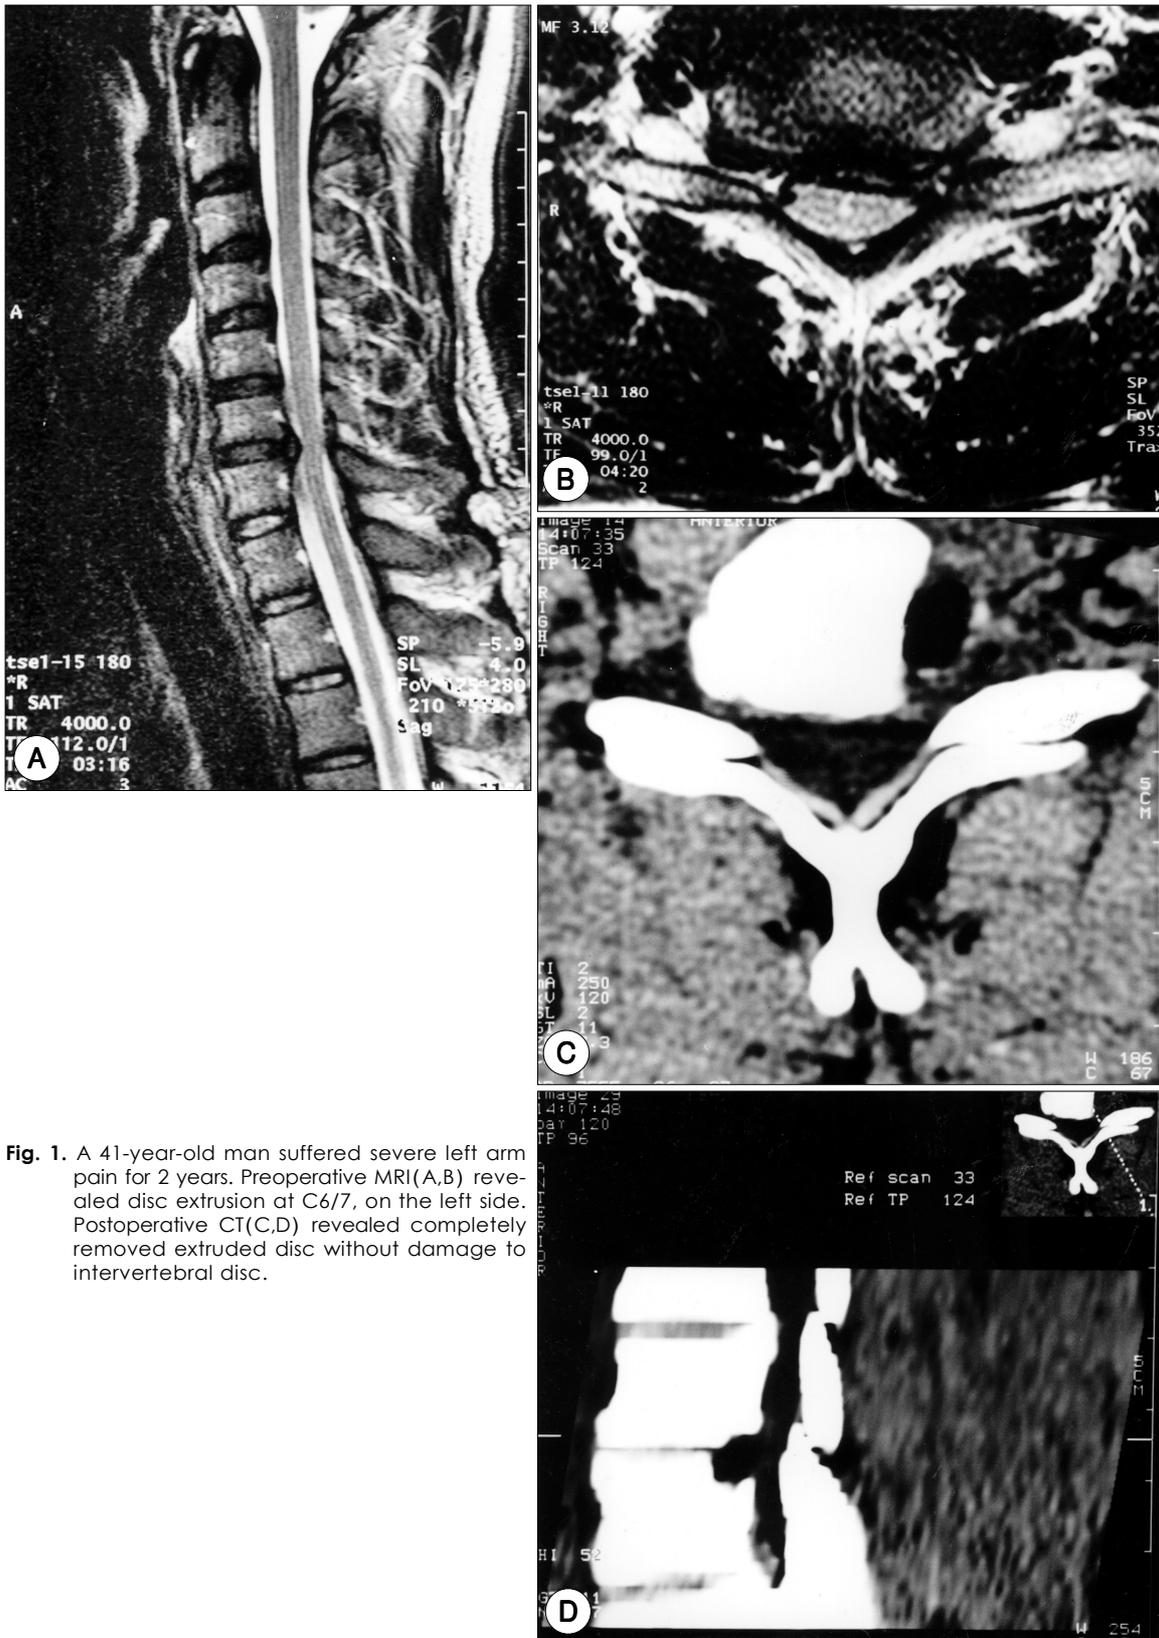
A 41-year-old man suffered severe left arm pain for 2 years. Preoperative MRI(A,B) revealed disc extrusion at C6/7, on the left side. Postoperative CT(C,D) revealed completely removed extruded disc without damage to intervertebral disc.
